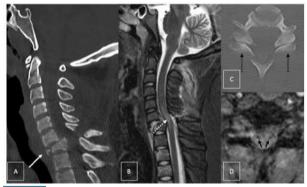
19-year-old female presenting after 20-30 ft. uncontrolled fall from the border wall. Sagittal CT of the cervical spine (A) demonstrates a severe flexion-dislocation injury at the C7 spinal level resulting in a hemorrhagic cord contusion (arrows). Note the bilateral locked facets on the axial bone window (solid black arrows, C). Sagittal STIR sequence demonstrates extensive cord edema (dashed white arrow, B). Axial MEDIC image demonstrates gradient susceptibility within the ventral cord, consistent with cord hemorrhage (solid black arrows, D)
